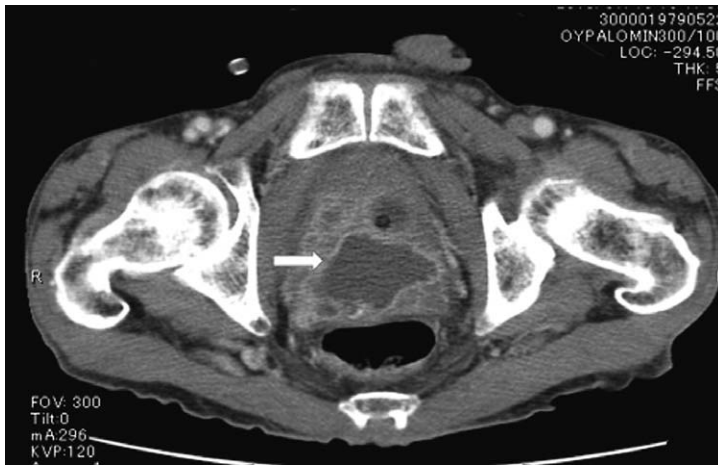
CT (arrow : abscess cavity)
